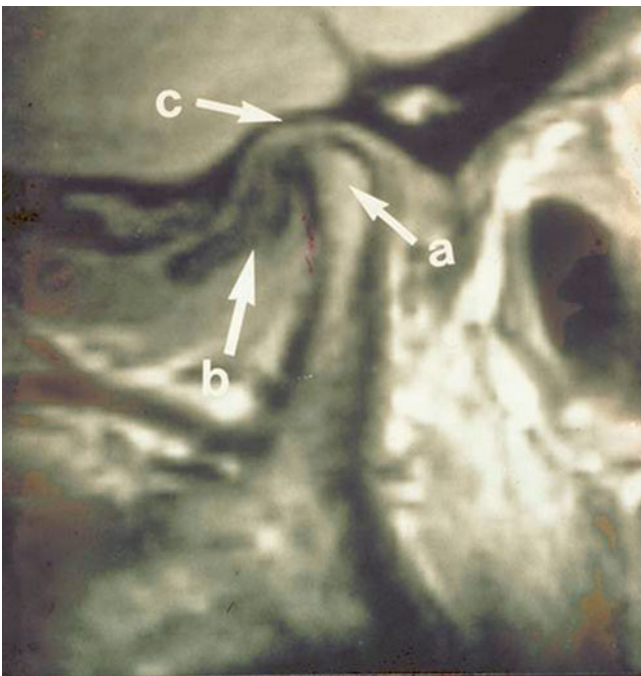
MRI image of the temporomandibular joint complex. Note arrow “b” identifies the TMJ disk. Hard tissue, such as the head of the condyle (a) and the roof of the glenoid fossa (c), contains less water and therefore cannot generate the signal strength necessary for diagnostic detail
